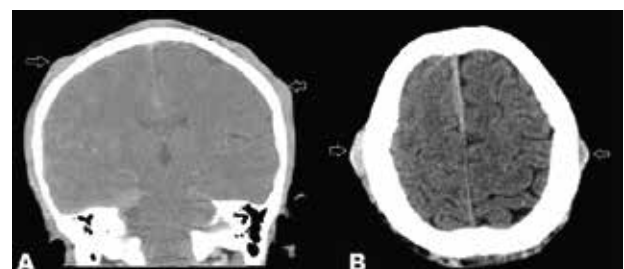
3- Coronal (A) and Axial CT (B) images showing multiple soft tissue scalp subcutaneous enhancing nodules – [white arrows].
